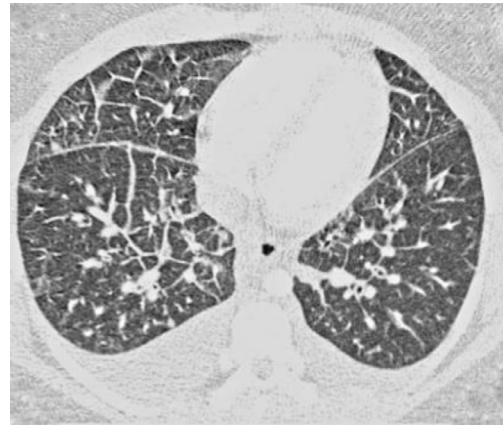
Thoracic CT revealing regular septal thickening, ground-glass opacities, and bilateral pleural effusion.
